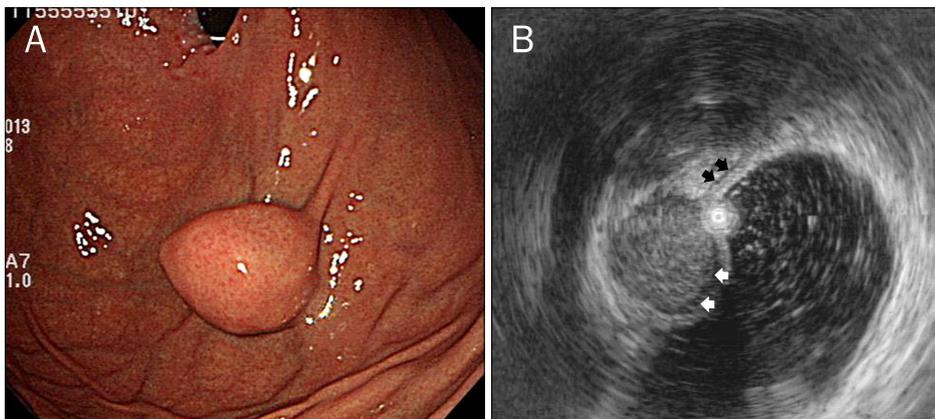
Endoscopic (A) and endosonographic (B) findings in a 59-year-old woman with a gastric schwannoma. (A) Endoscopy shows a submucosal elevated lesion with type I morphology according to Yamada's classification in the greater curvature of the body. (B) On EUS, the mass is homogeneous and its echogenicity is similar to that of the normal proper muscle layer (black arrows). It measures 32.0x21.0 mm in size and a marginal halo (white arrows) is observed.
